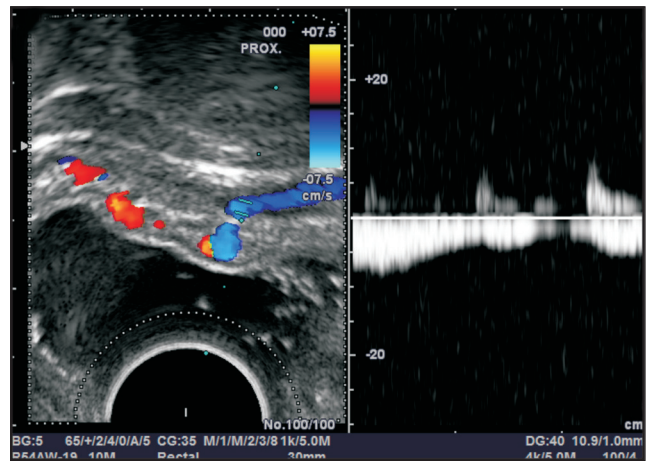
Application of pulse Doppler confirmed the venous nature of the outflowing vessel in the anterior wall of rectum
